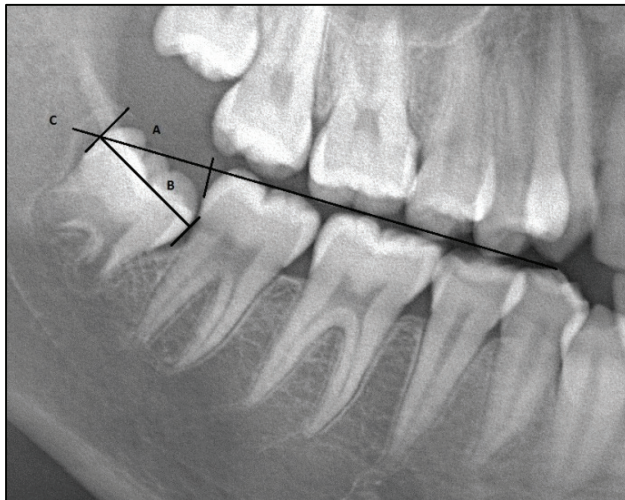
A sectioned panoramic radiograph. Distance between distal border of second molar crown and anterior border of ramus measured on occlusal plane (*A*) in proportion to width of third molar crown (*B*) for upper and lower third molars as well, *C* = occlusal plane.
